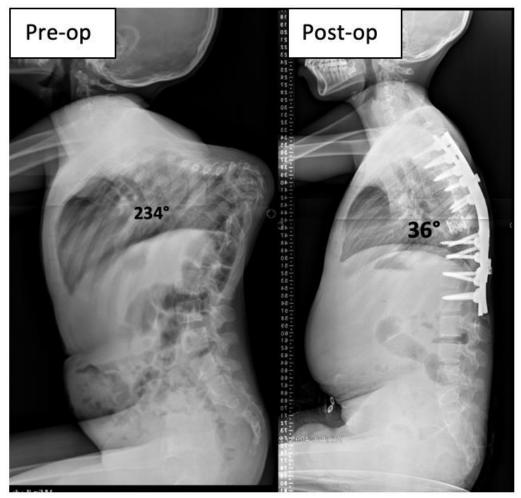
Radiographic images of case example.
